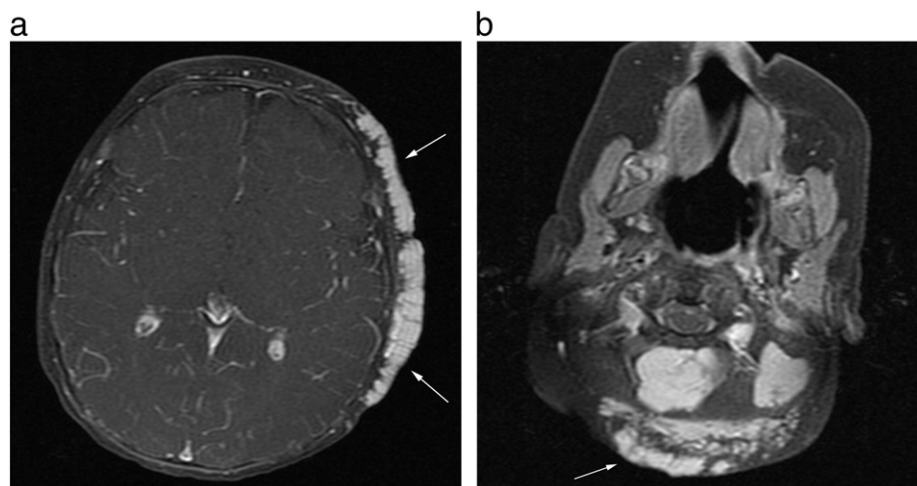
Axial fat-suppressed contrast-enhanced T1-weighted images show enhancing lesions along the left frontal, parietal, and suboccipital scalp (arrows), which represent infantile hemangiomas and correspond to the physical examination findings in Fig. 1.
